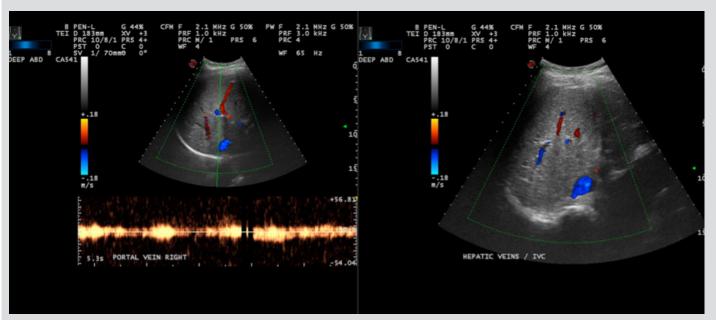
Follow-up Doppler and colour flow mapping with no sonographic evidence of thrombosis. The portal vein at the porta hepatis and its main right and left branches show normal colour filling
